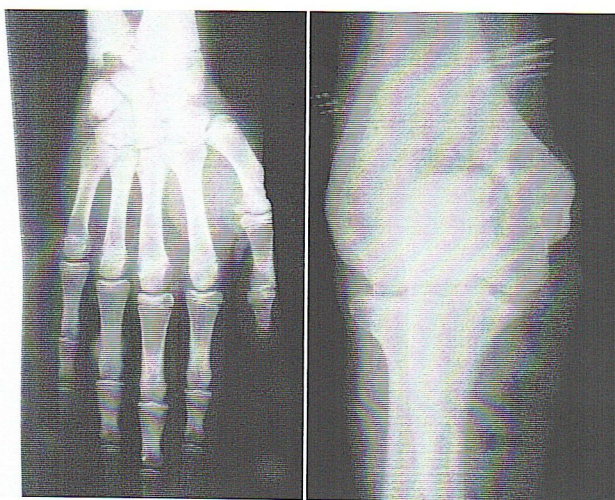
Hand-wrist X-rays: underage boy (left)
